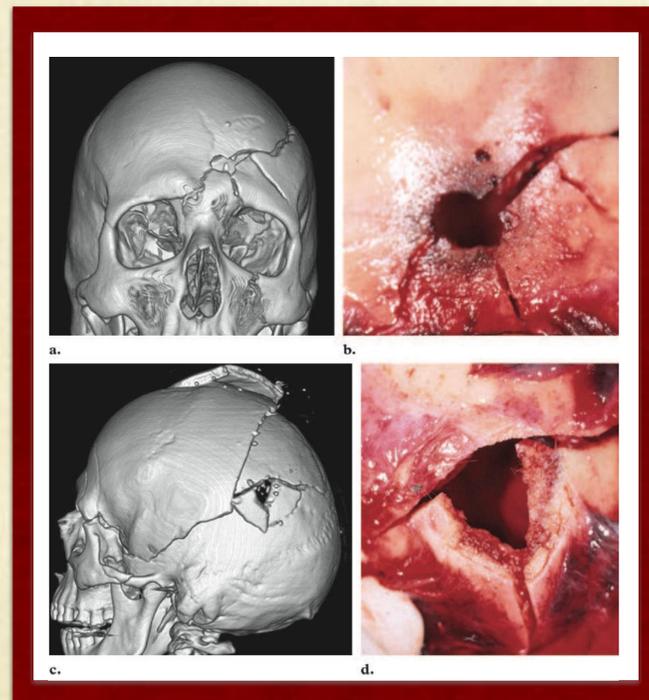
Image #2. Entrance and Exit wounds. (a) A 3D CT reconstruction of an entrance wound. (b) Autopsy picture of the same entrance wound. (c) The exit wound on a 3D CT reconstruction. (d) The same exit wound found during an autopsy.¹
